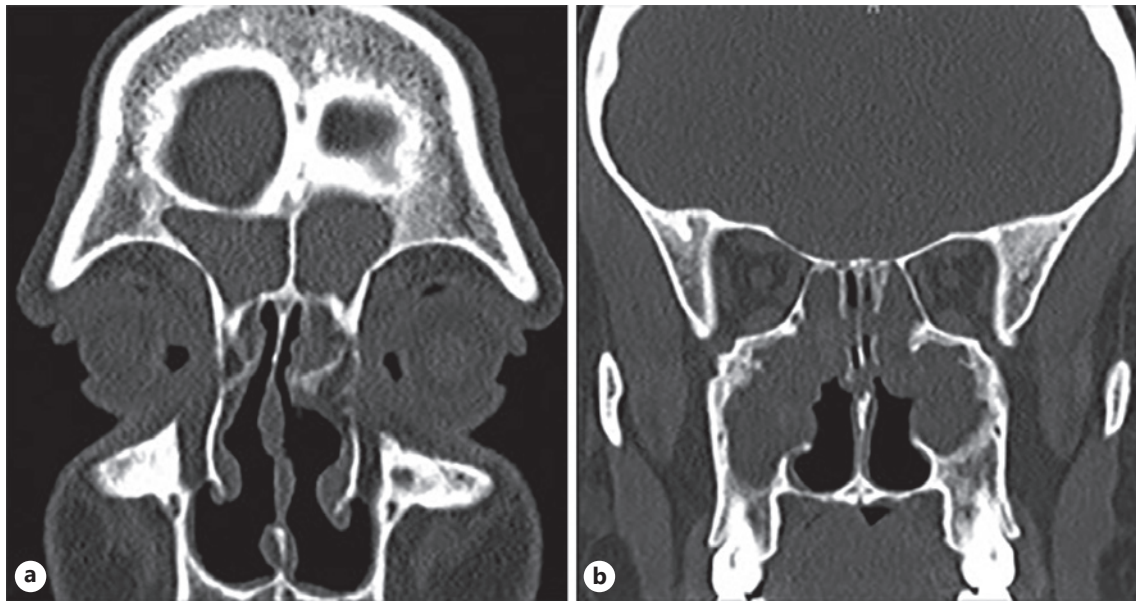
Representative preoperative sinus CT scans, coronal view. a Frontal sinus disease. b Maxillary and anterior ethmoid sinus disease.
